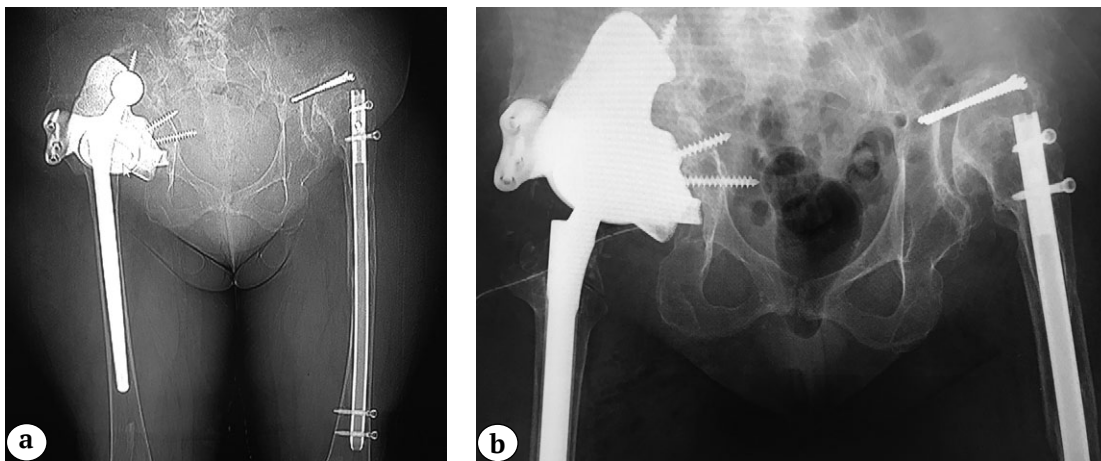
Pelvis X-rays after revision total hip replacement:
